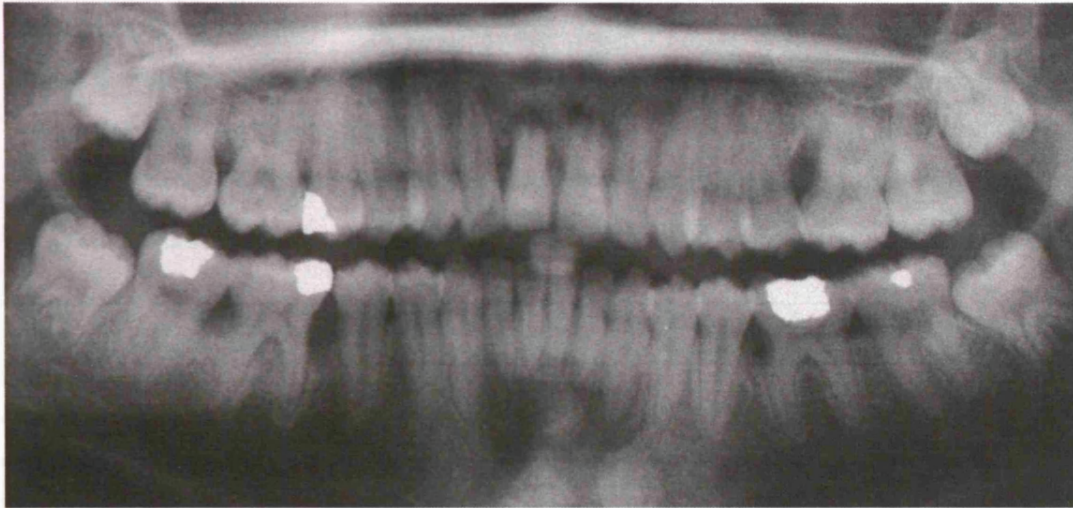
Orthopantomograph of the patient described in paragraph 5.2.2. Localised bone loss is present around 16 (UR6), 11 (UR1), 26 (UL6), 36 (LL6) and 46 (LR6).
